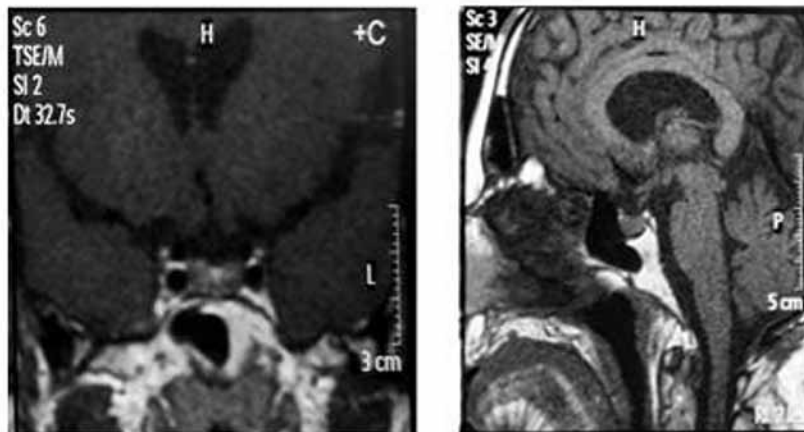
8 × 7 mm diameter microadenoma showing heterogenous enhancement with contrast was detected posteriorly on the pituitary MRI examination
